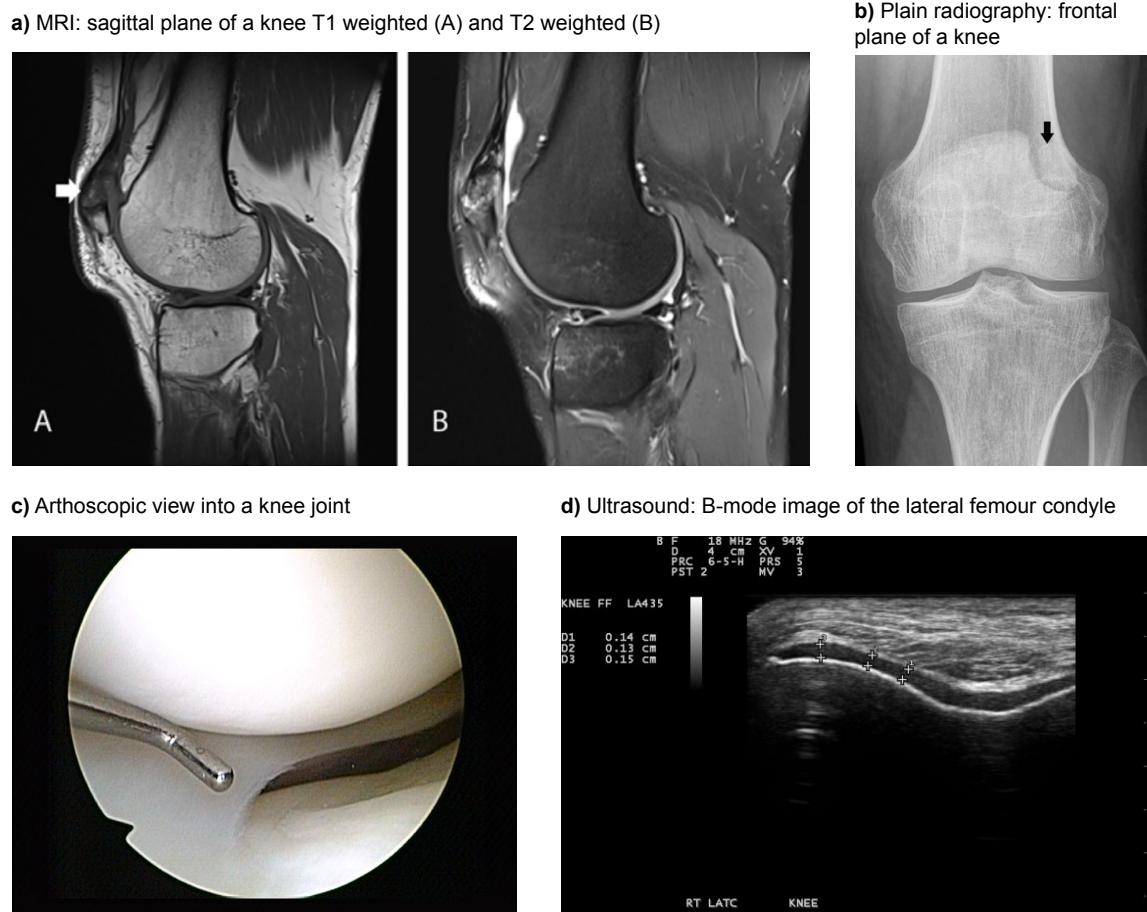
Examples of clinical imaging methods on healthy articular cartilage. a) Sagittal MRI images of a knee with different relaxation time weightings.^a b) Plain radiography of a knee in frontal plane.^b c) Arthroscopic view into a knee joint showing cartilage of femur and tibia.^c d) Ultrasound B-mode image of the lateral femur condyle. The anechoic zone represents the cartilage.^d
